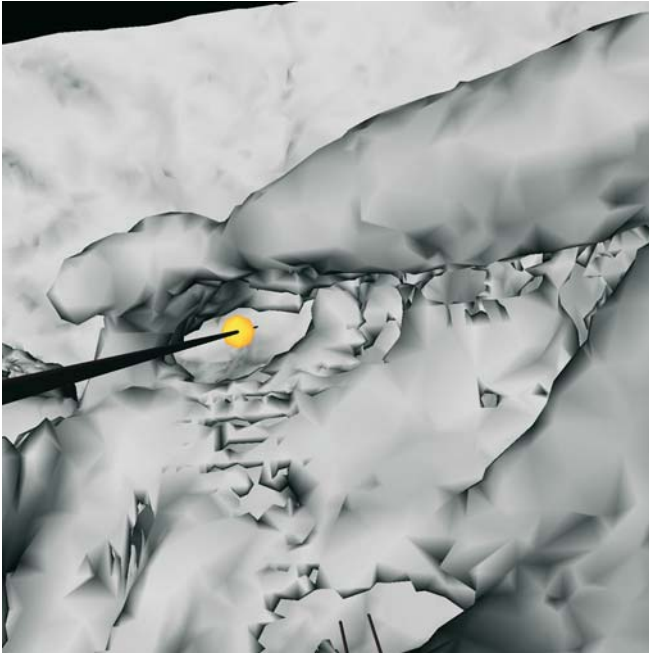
Sella. Paramedian view right (3-D CT, patient K.C.)
